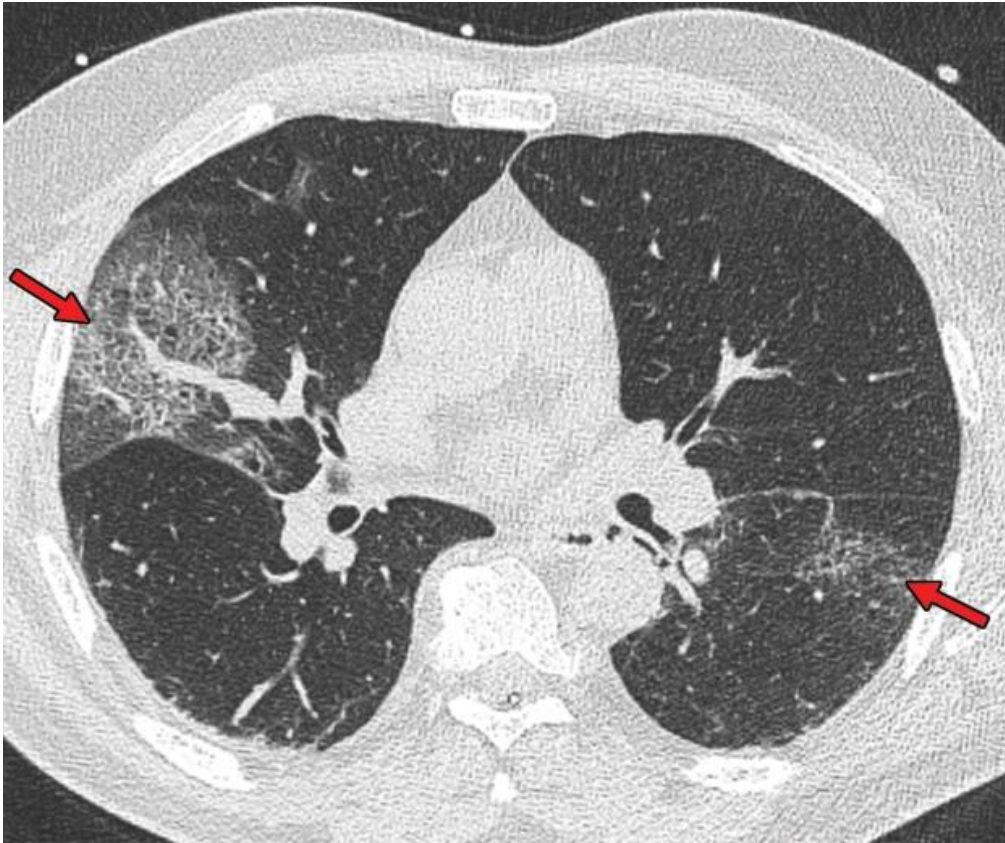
chest HRCT images in a 55-year-old woman with severe COVID-19
